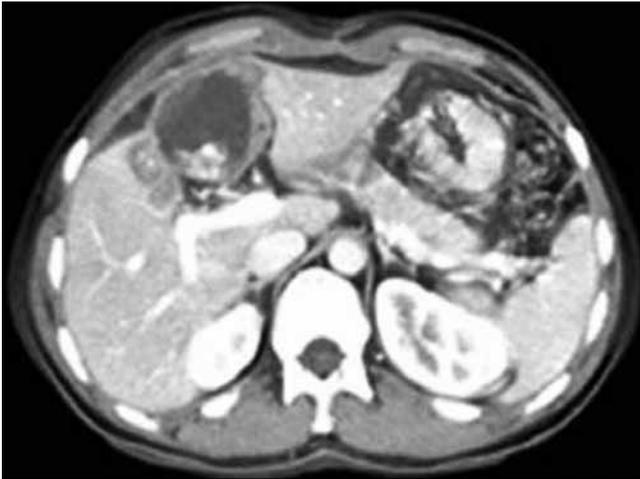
Preoperative abdominal computed tomography images show a 6 cm-diameter cystic mass in 4a and 4b segments of the liver with common hepatic artery invasion in addition to compression of vena portae and common hepatic duct.
